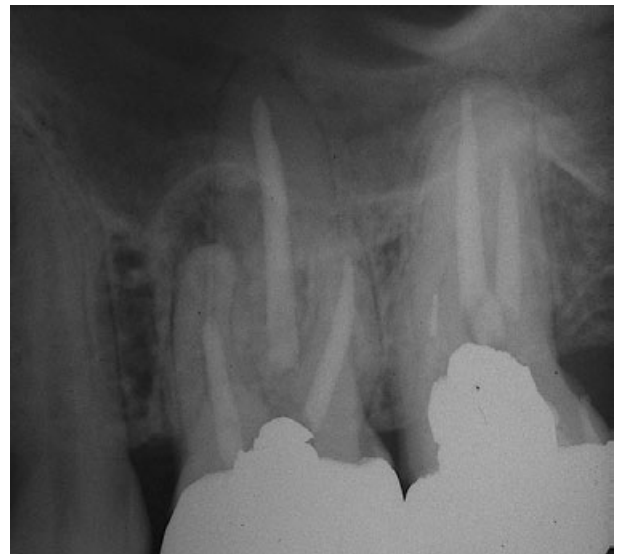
Endodontically treated tooth 26 presented with periapical lesion associated with mesiobuccal root.
